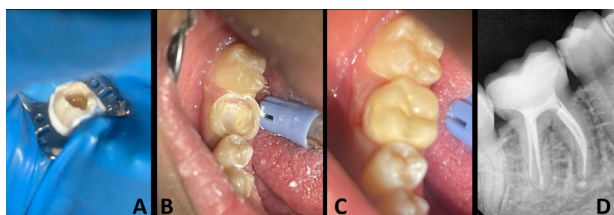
A: during root canal treatment, B: modification of the tooth for the endocrown preparation, C: after endocrown cementation, D: preapical X-ray of the cemented restoration.
